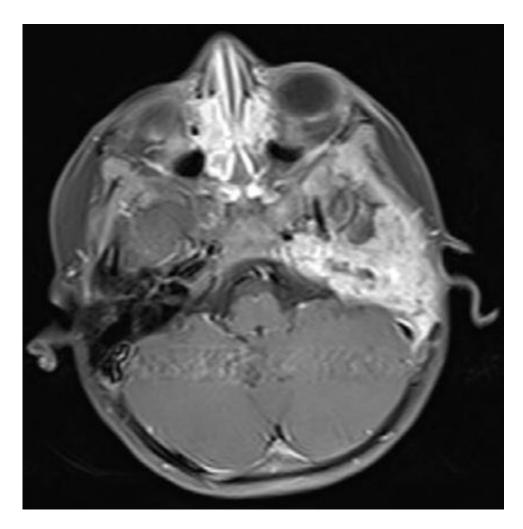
Langerhans cell histiocytosis of temporal bone.Complementary contrast enhanced MRI axial image in the same patient shows an ill-defined heterogeneously enhancing lesion involving the left temporal region (arrows).
